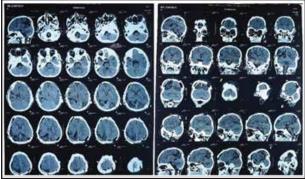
Postoperative CT scan picture of this CP patient.
